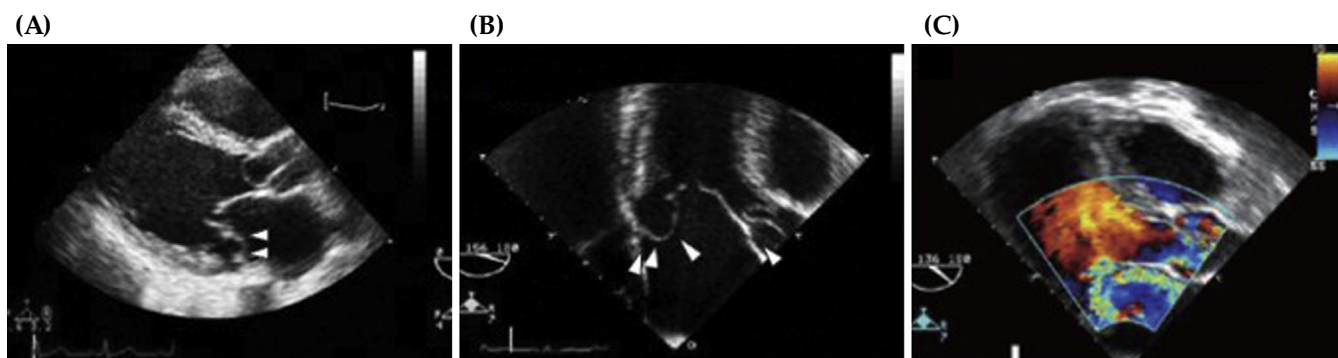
A case of mitral valve prolapse in the basal portion with severe mitral regurgitation in a 42-year-old man with BD [169]. (A) Transthoracic echocardiography showing mitral valve prolapse, predominantly involving the basal portion of the posterior mitral leaflet (white arrowheads), together with aneurysmal changes of the aortic valve. (B) Transesophageal echocardiography (156 degree) showing mitral valve prolapse in basal portion of the mitral leaflet (white arrowheads). (C) Transesophageal echocardiography (136 degree) showing severe mitral regurgitation. Adapted from Yoon et al. [169].
